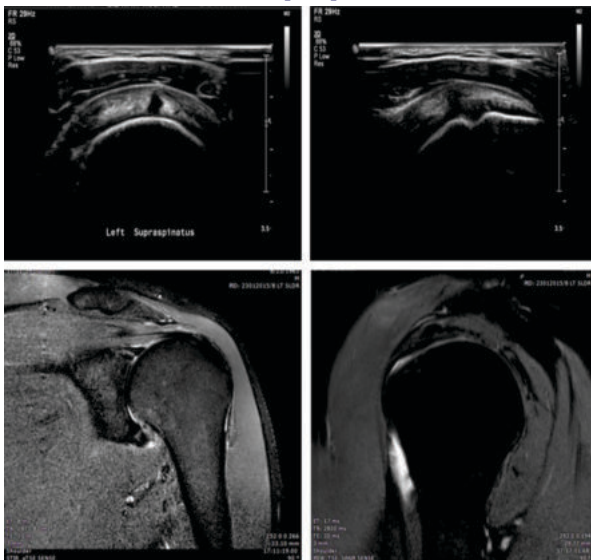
(a,b) USG images in transverse and oblique showing partial thickness tear of supraspinatus tendon. (c,d) MRI coronal and sagittal images showing the same.
